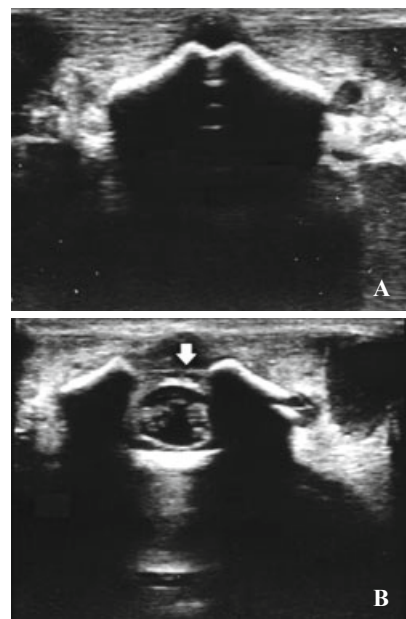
A: At the level of L1, normal sonographic appearance; B: At the level of L2, arrow indicates the fusion defect of the posterior vertebral arches.
